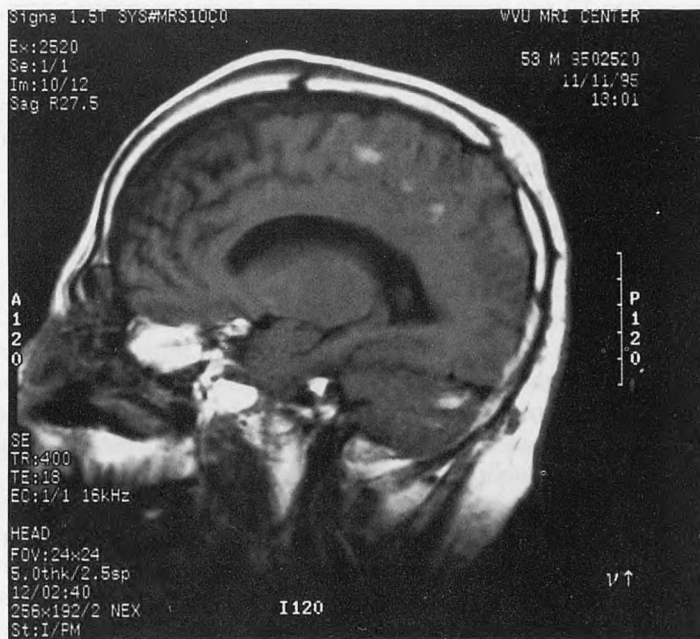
MRI scan in a comatose patient with closed head injury showing diffuse axonal injury changes. While large hematomas with mass effect are ordinarily not seen, diffuse axonal injury represents widespread shearing of axons and multiple areas of injury.
